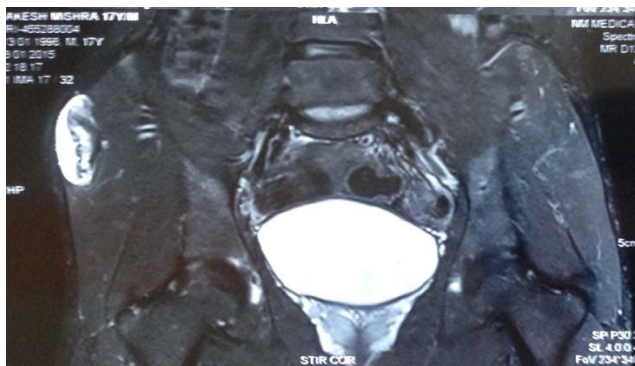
The MRI cuts clinched the diagnosis of Sessile Exostosis from the Anterior Superior Iliac Spine
